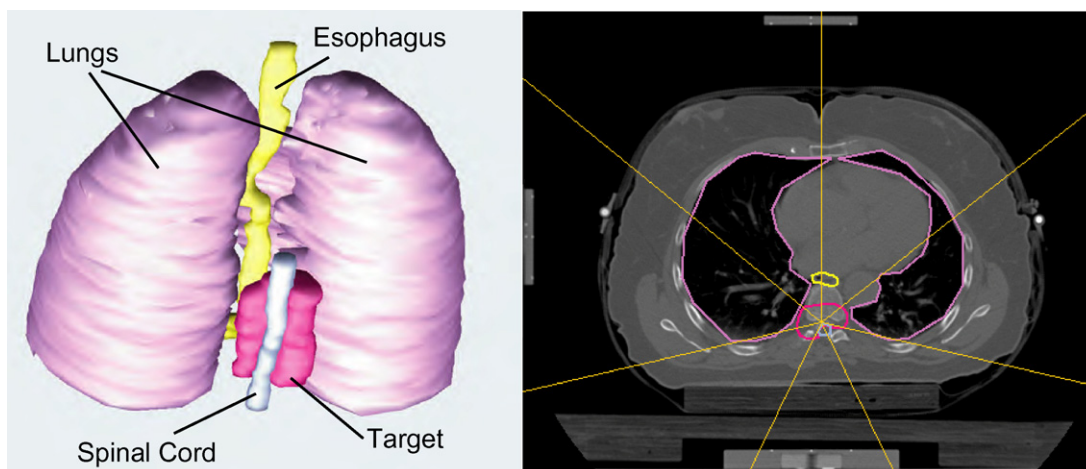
3D-rendered structures (left side) and exemplary CT slice with beam arrangement (right side) of the paraspinal case.
